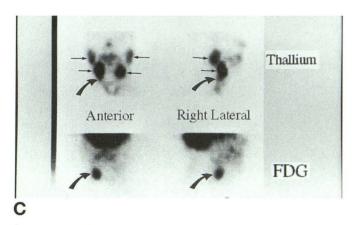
A, CT images through the base of the tongue show no definite evidence of tumor.
